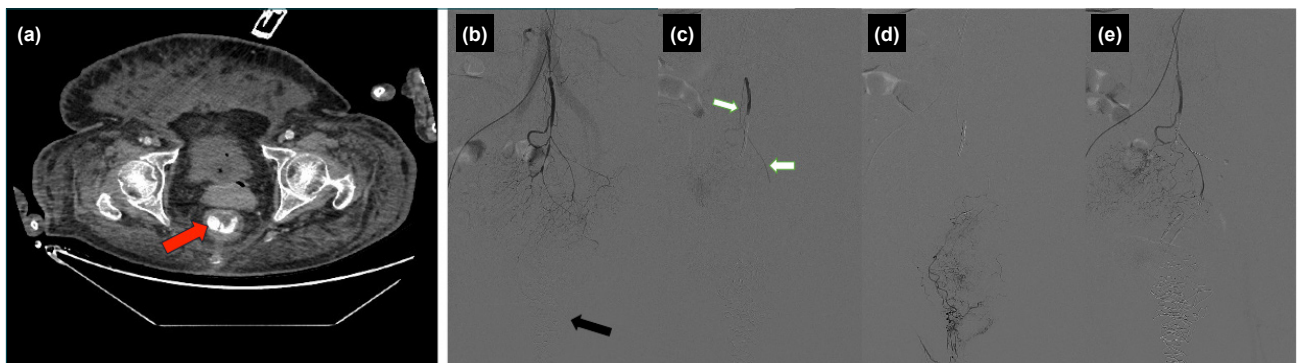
(a) A 73-year-old patient followed up in intensive care unit developed massive rectal bleeding and CT examination performed with only intravenous contrast material without oral and rectal contrast material showed active contrast extravasation (red arrow). (b) DSA images obtained after IMA catheterization of the same patient showed no active contrast extravasation. The black arrow shows an anal tampon applied by the general surgery team. (c) SRA is observed with developed spasm due to bleeding (white arrows). (d) Superselective catheterization of the spastic SRA shows contrast enhancement of the hemorrhoidal plexus and CCR. (e) No residual SRA branch was observed after embolization with 2mm and 3mm coils.
